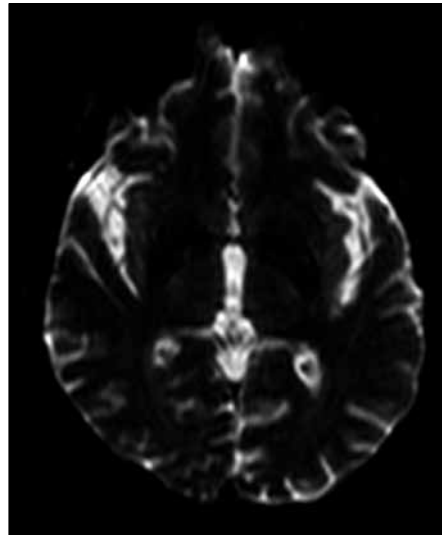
Diffusion-weighted magnetic resonance imaging of basal ganglia showing normal appearance.
